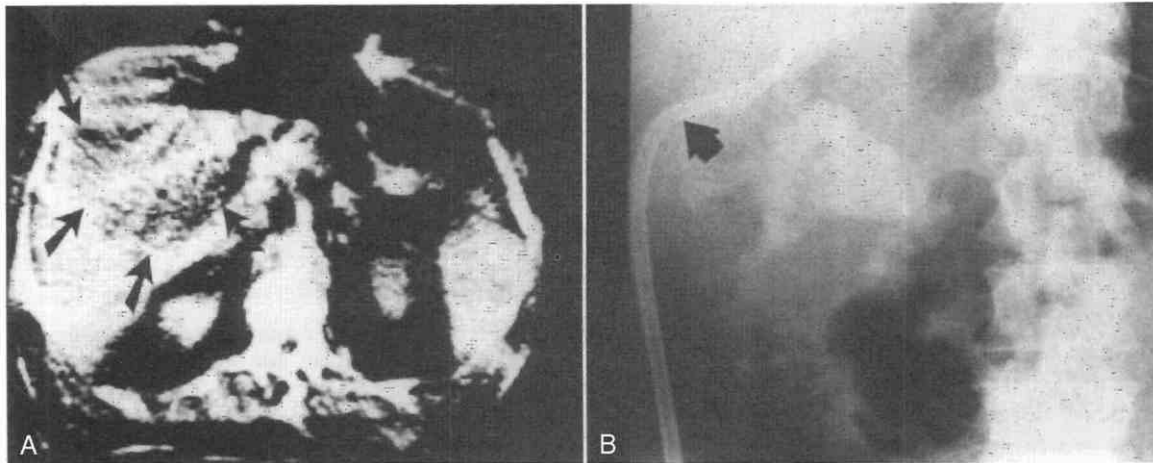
A, First CT-guided drainage of an abscess (arrow) performed in 1975 by the author. B, Plain radiograph of the abdomen shows a drainage tube in place (arrow). The patient recovered uneventfully. (B, From Haaga JR, et al: Definitive treatment of a large pyogenic liver abscess with CT guidance. *Cleve Clin Q* 43:85–88, 1976.)
